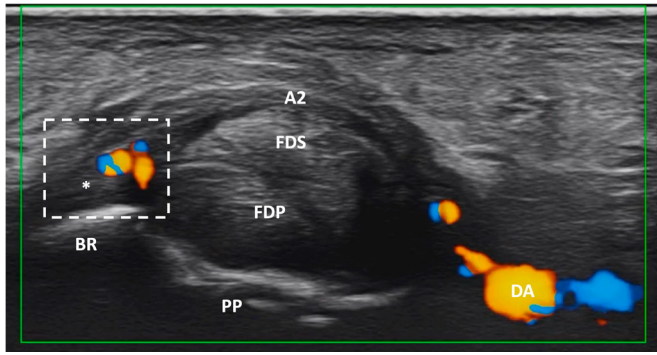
US-detected Doppler signal within the A2 pulley enthesis in early psoriatic arthritis (PsA). Transverse image obtained at the level of the radial enthesis of A2 pulley (second right finger) of a patient diagnosed with early PsA. The colour Doppler signal reveals active inflammation at the insertion of the pulley (dashed white box). *Enthesis of A2 pulley. AZ, second annular pulley; BR, bony ridge; DA, proper palmar digital artery; FDP, flexor digitorum profundus; FDS, flexor digitorum superficialis; PP, proximal phalanx.
